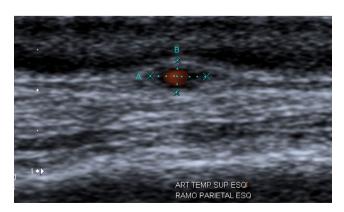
Temporal echo-Doppler of left temporal artery showing an edematous halo
